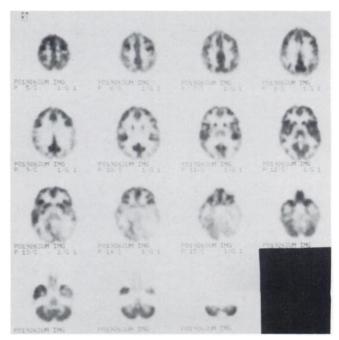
FDG study with the 831 tomograph. This interictal study of a partial epilepsy patient is displayed with the subject's right on the images' left. Both investigators reported left mesial temporal, lateral temporal and occipital hypometabolism.
